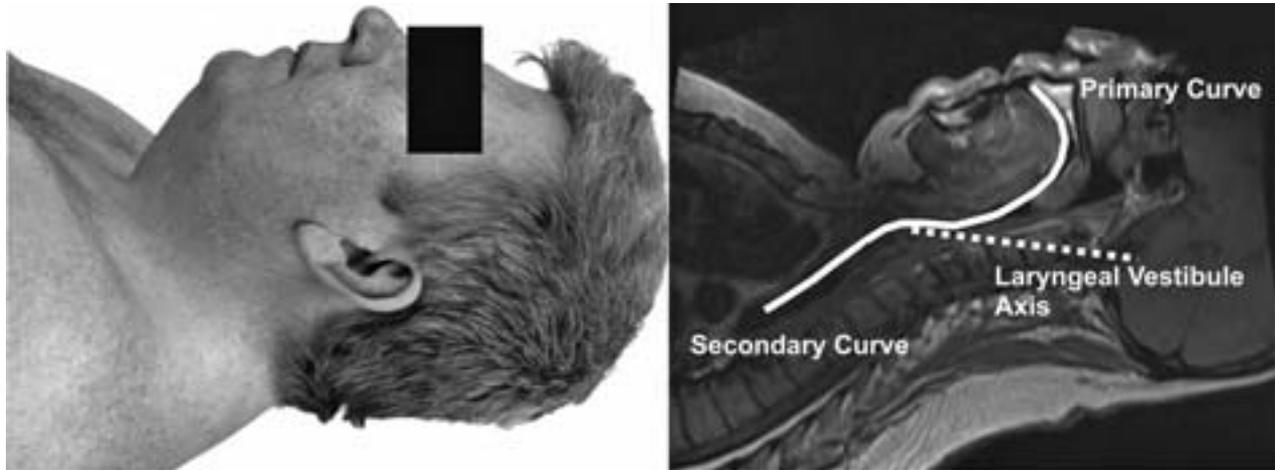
Magnetic resonance imaging of a patient on left with a short, thick neck positioned on one pillow. Note the laryngeal vestibule axis is upsloping. Further ramping of the head and neck position is required before laryngoscopy is attempted. (Consent for publication of the photograph and magnetic resonance imaging scan was obtained from the patient.)
